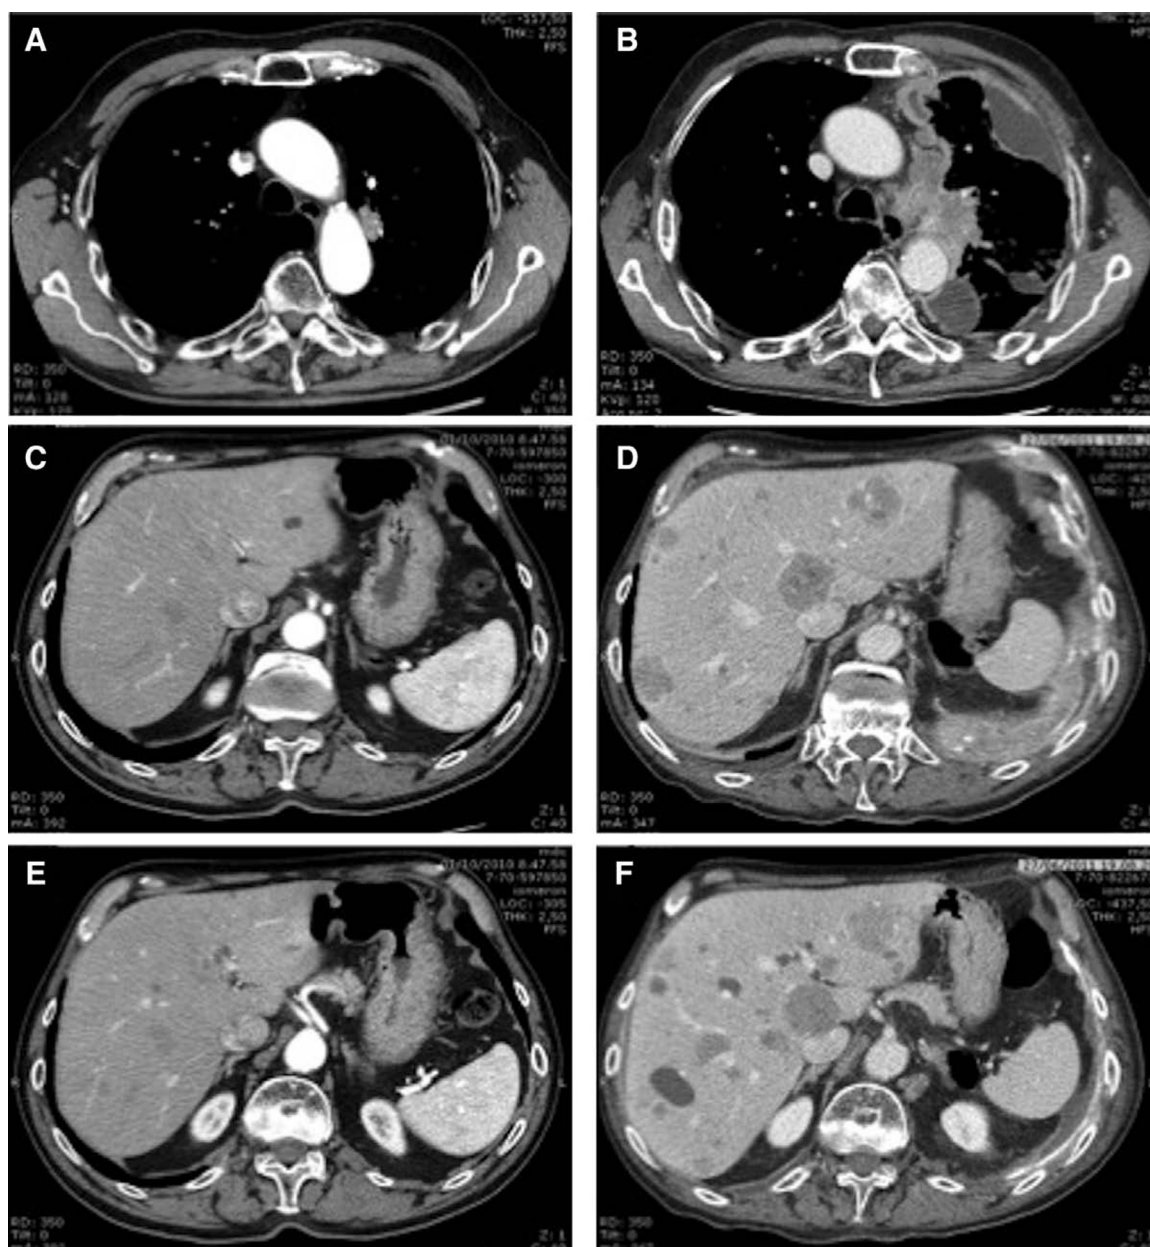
Comparison of baseline (A) and end-treatment (B) contrast-enhanced CT scans in patient no. 4. End-treatment CT scan was performed 35 days after peptide receptor radionuclide therapy. Transaxial images showed progression of disease in left lung. CT, computed tomography.
